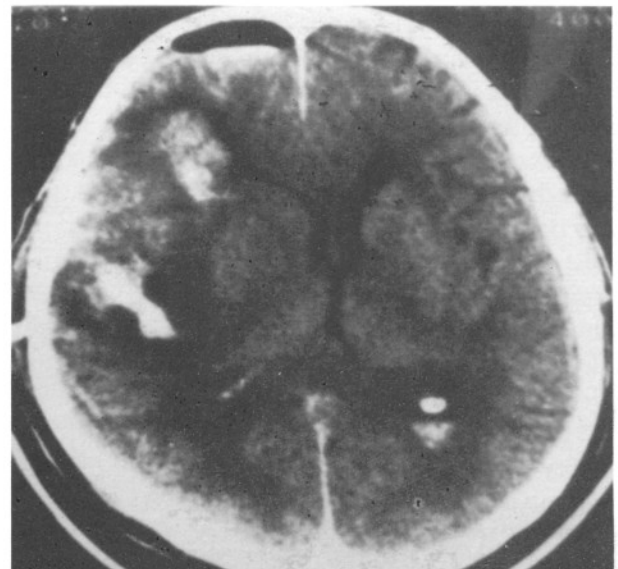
CT appearance of the lesion on the fifth day post-operatively
